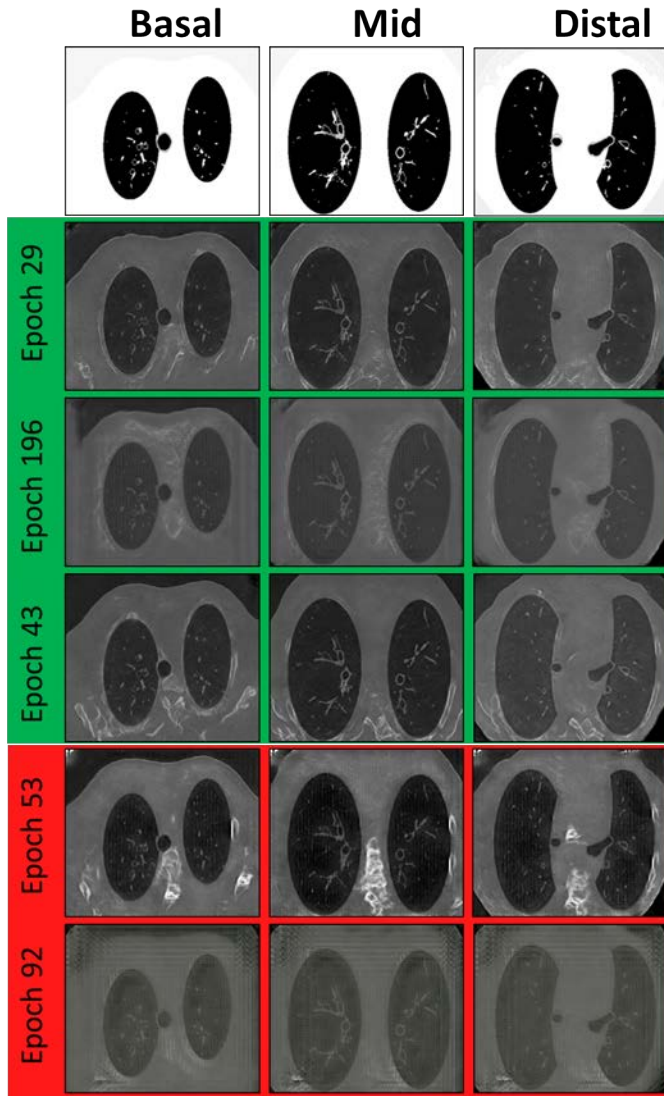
Generated CT virtual scans for 3 representative sketches: images from Pareto front epochs in green frame and images from non-Pareto epochs in red one.
